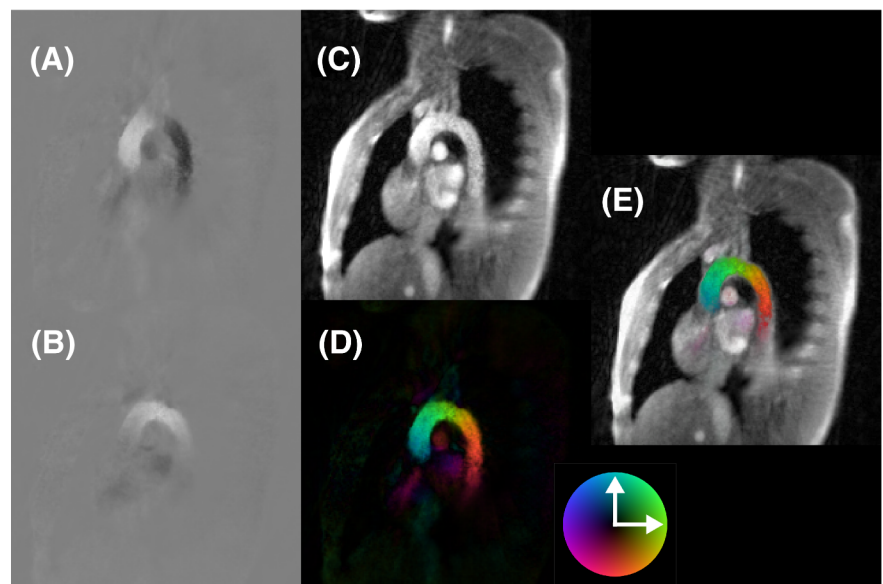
Peak-systolic frames of a real-time 2d flow MRI study of the aortic arch at 53 ms temporal resolution, i.e. 19 fps. (a) PC map in foot-head direction, (b) PC map in anterior-posterior direction, (c) magnitude image, (d) in-plane speed image, and (e) overlay image of (c,d)
